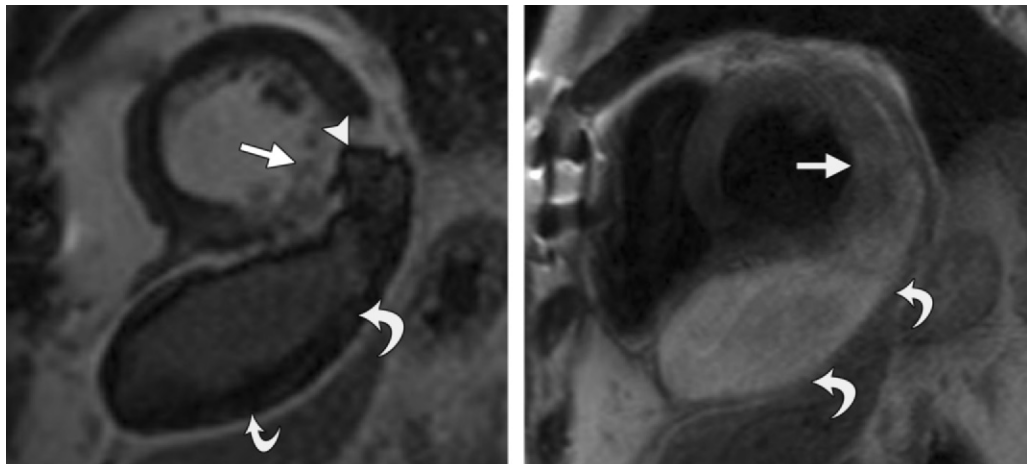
Hemorrhagic pericardial effusion in a 47-year-old man. (a) Short-axis delayed-enhancement image shows a full-thickness transmural infarct (straight arrow) in the midinferolateral and inferior walls. There is a dark area of hemorrhagic microvascular obstruction (arrowhead) within this scar, which is continuous with a large collection in the pericardium (curved arrows) that has high signal intensity within it, consistent with a hemorrhagic pericardial effusion. (b) Short-axis T2-weighted black-blood image shows myocardial edema (straight arrow) and high-signal-intensity pericardial effusion (curved arrows).
